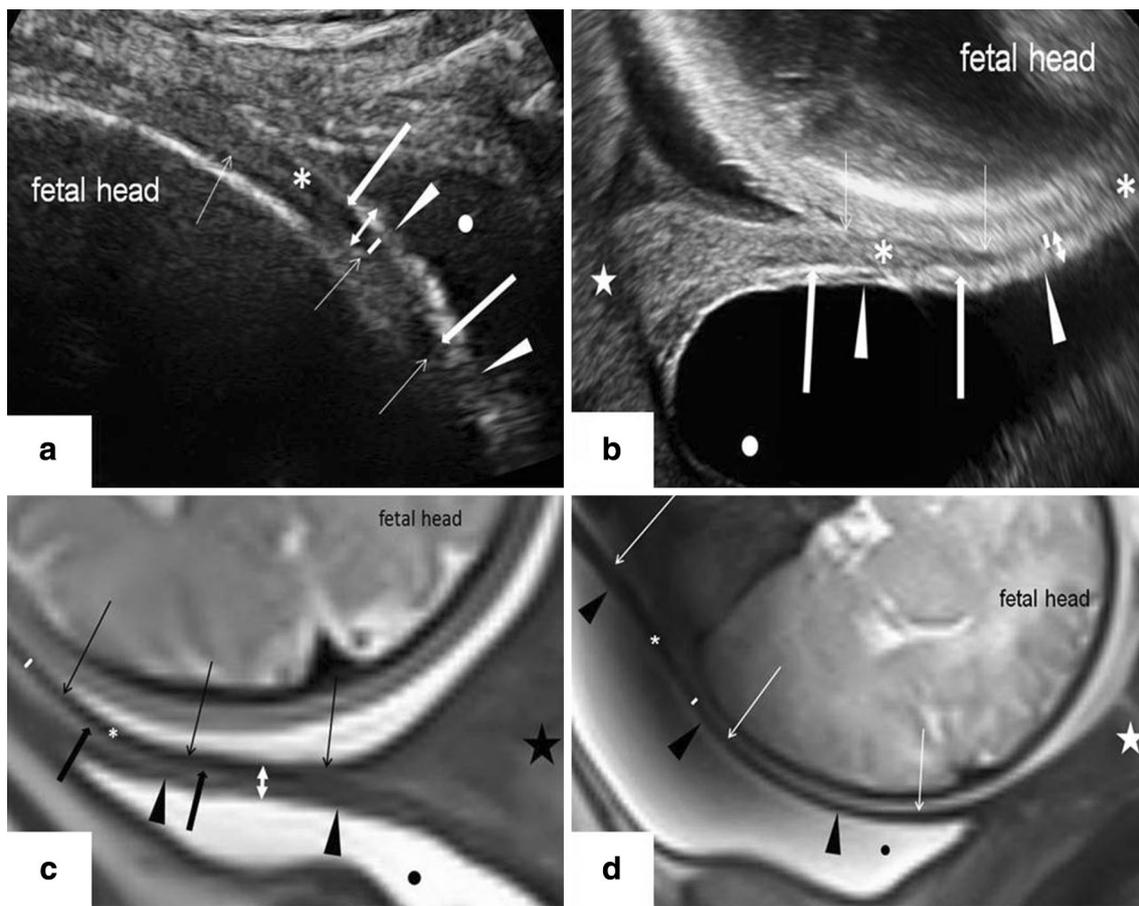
Thickness measurements of the lower uterine segment (LUS) using transabdominal (a) and transvaginal (b) ultrasound and MRI (c, d), determined at the thinnest point. *Thin arrows* interface decidua/amniotic fluid, *bold arrows* interface LUS/urinary bladder wall, *arrow heads* interface urinary bladder wall/urine, *asterisk* LUS, *point*
